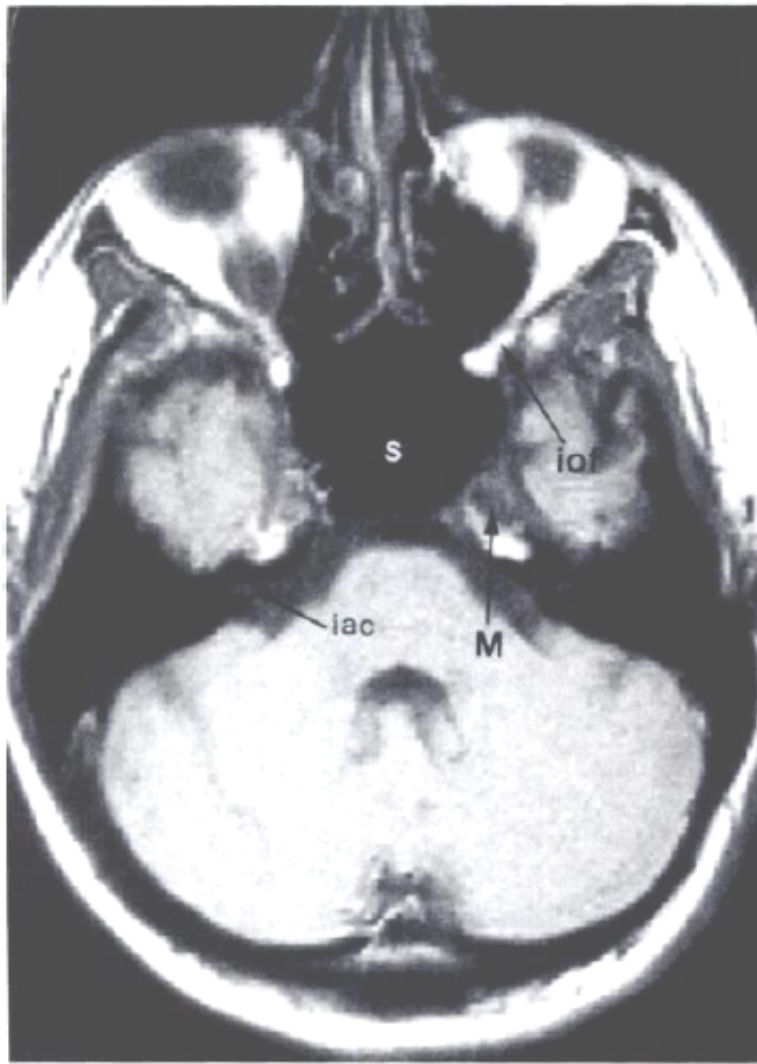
Axial T1-weighted MR images of the skull base, arranged from caudal (a) to rostral (d). *C* = clivus, *ca4* = cavernous portion of carotid artery, *iac* = internal auditory canal, *iof* = inferior orbital fissure, *LM* = lateral pterygoid muscle, *LP* = lateral pterygoid plate, *M* = Meckel cave, *MM* = medial pterygoid muscle, *MP* = medial pterygoid plate, *np* = nasopharynx, *P* = pterygoid process, *p* = pterygoid fossa, *pg* = pituitary gland, *S* = sphenoid sinus, *sof* = superior orbital fissure.
